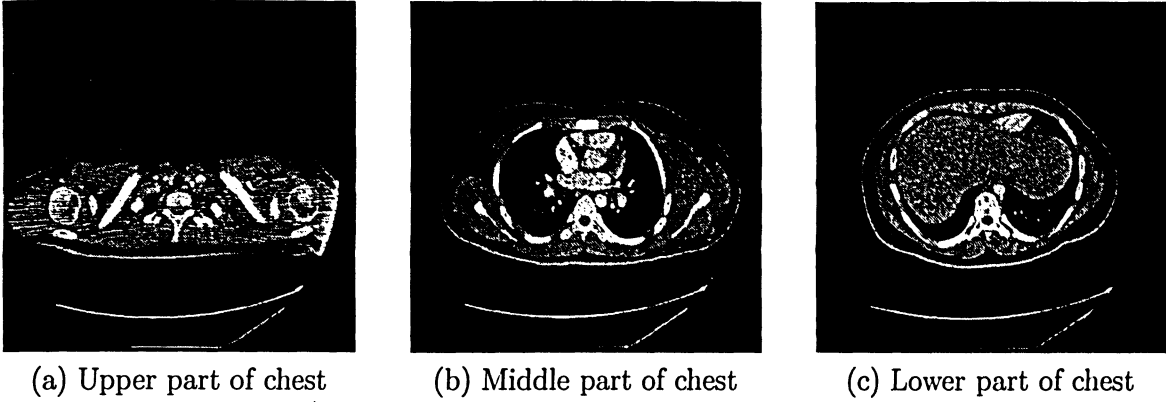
CT images of different parts of chest.
